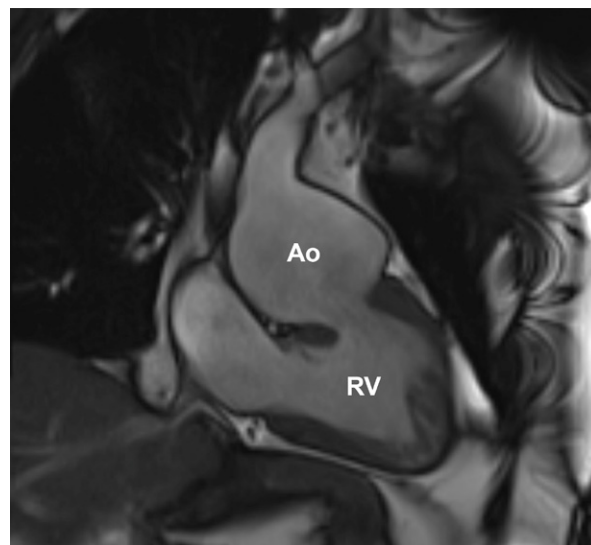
Cardiac magnetic resonance image shows a ventriculoarterial connection between the patient's systemic right ventricle (RV) and aneurysmal aorta (Ao). Note RV dilation and hypertrophy.
